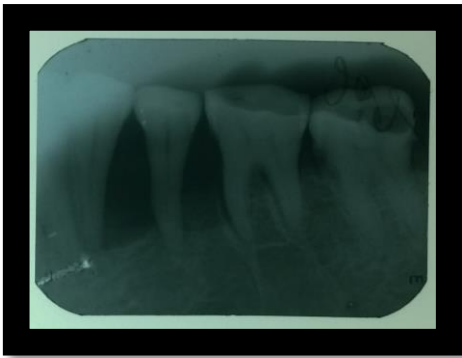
Intra Oral Periapical Radiograph showing vertical bone loss.
